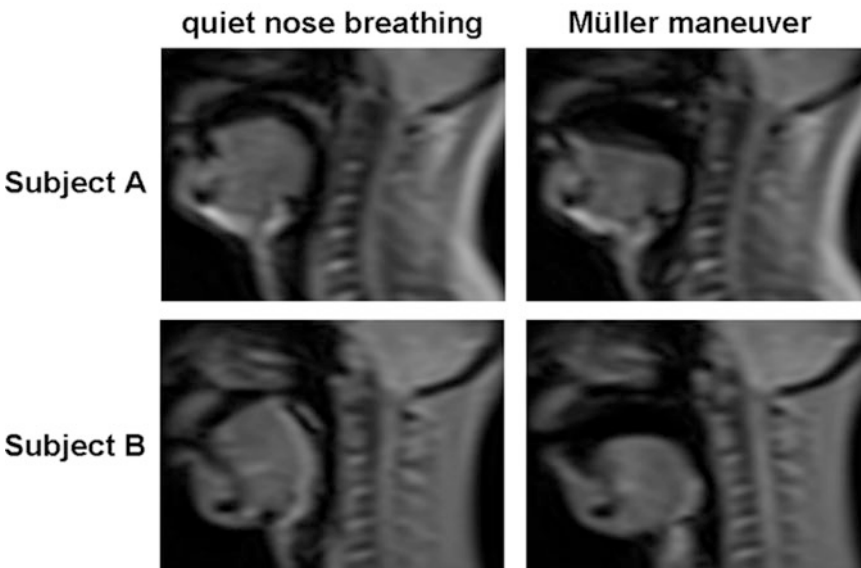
Examples of MR images in two representative subjects before and during the Müller maneuver. In both subjects the tongue moved posteriorly and became flattened, but the patterns of airway narrowing were
